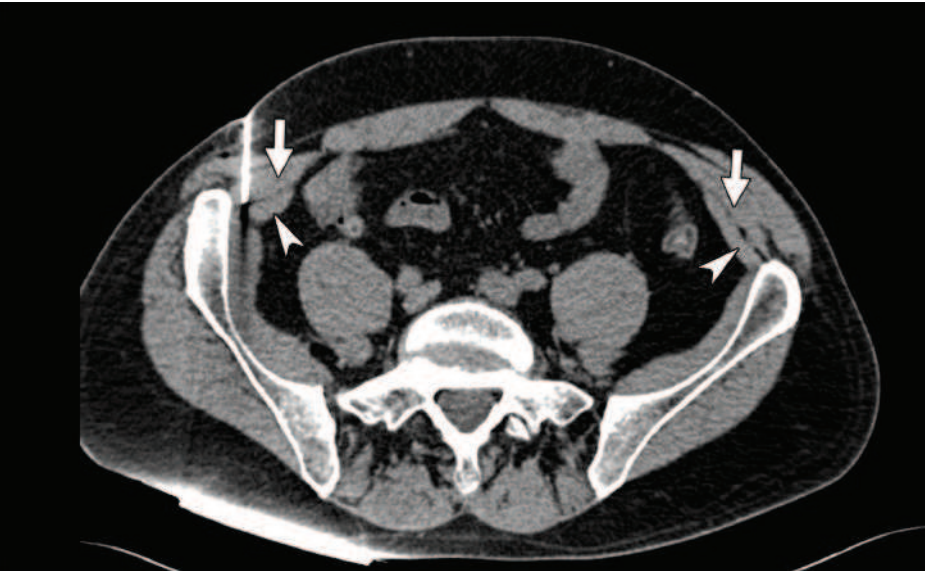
CT scan showing 22 Gauge RF needle in place at defined target.
